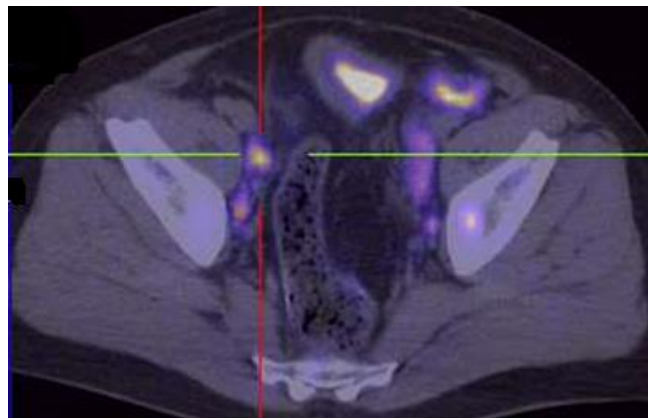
$^{18}\text{F}$ -FCH PET/CT scan showing increased tracer uptake in the right iliac lymph nodes (Patient after RP; PSA= 1.5 ng/mL)
